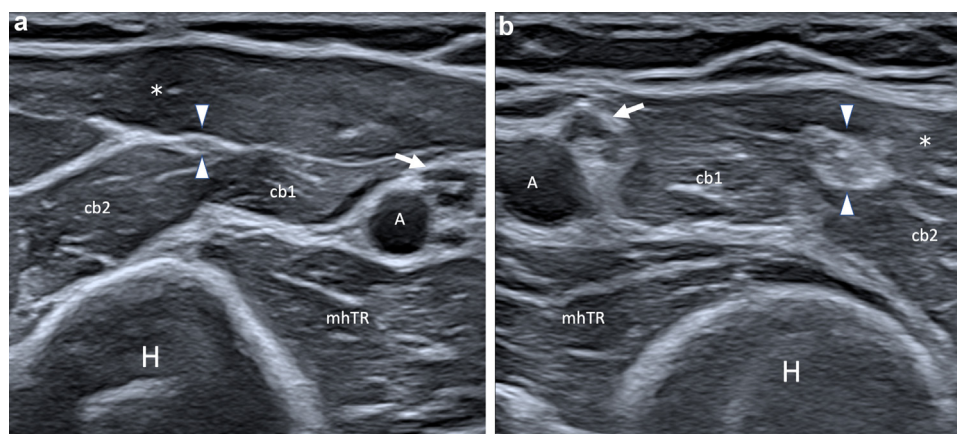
High frequency Ultrasound (18–5 MHz) comparative short-axis scan of the left (image a) and right (image b) proximal arm. The musculocutaneous nerve (white arrowheads) in between the biceps muscle (white asterisk) and the two heads of coracobrachialis (cb1 and cb2) results enlarged with edematous fascicles in the affected arm (b): the pathologic changes in caliber and echotexture are more evident if compared with the contralateral musculocutaneous nerve (white arrowheads in a) and in relation with median nerve (white arrows). The biceps muscle in b is hypotrophic as consequence of denervation, without signs of fat atrophy. H=humeral; A=brachial artery; mhTR=Medial Head of Triceps.
